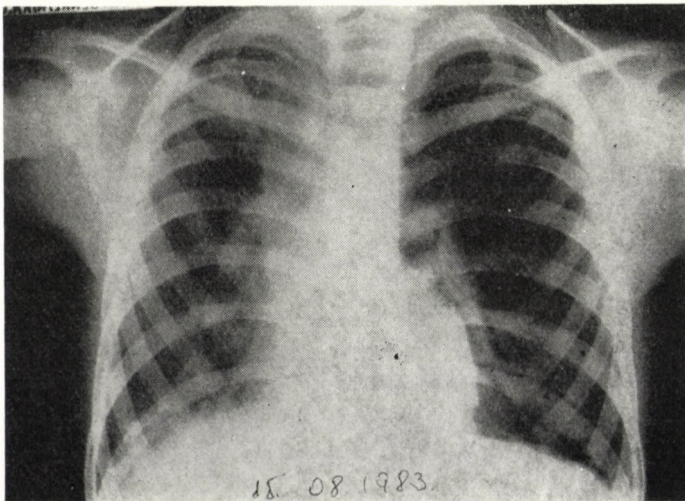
X-rays on 15 August, 1983: nearly normal finding, the mediastinal dislocation has almost completely disappeared, increased transparency of right lung
